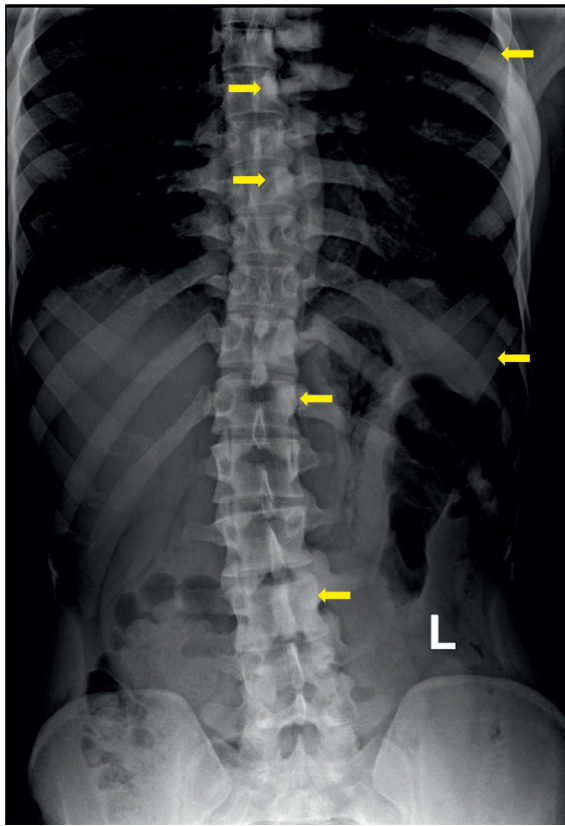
X-ray thoracic spine showing hyperostosis (arrows) involving left half of T1, T2, T4–7, T11, T12, L3–5 vertebral bodies, left 5th, 6th, 10th, 11th ribs.
